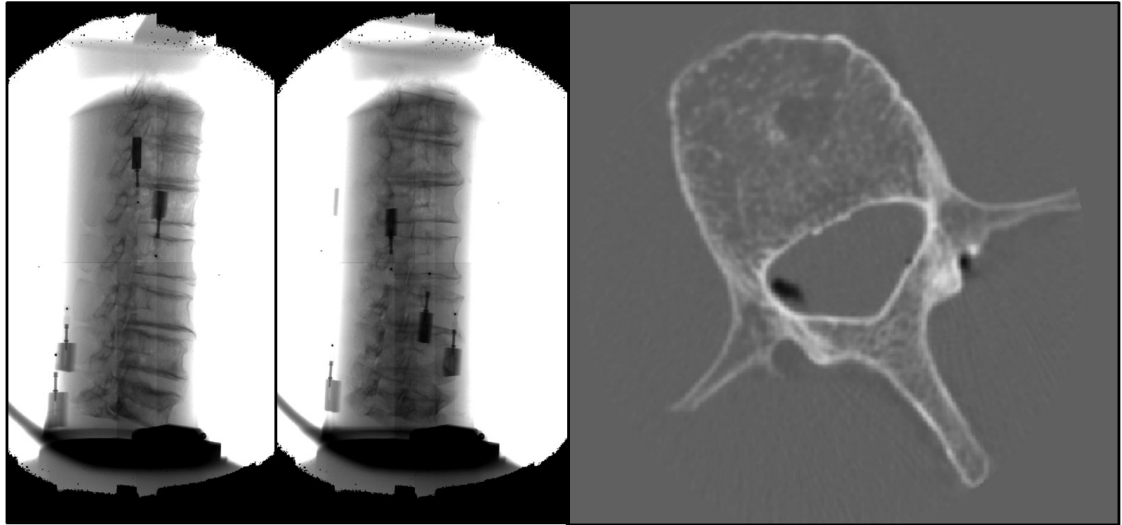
Example of images from gold standard dataset show fluoroscopy images (left) and CT cross section (right) of lumbar spine.
